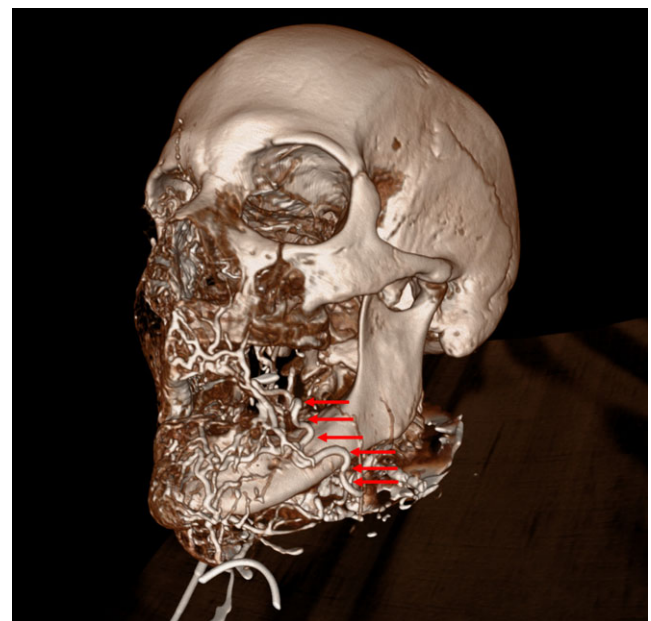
Three-dimensional reconstruction of a cranial CT scan showing the course of the contrasted facial artery (red arrows)
